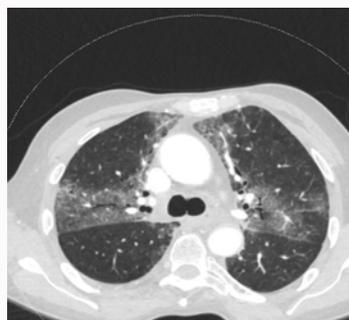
CT-scan with interstitial abnormalities of both lungs. These include ground-glass opacities and consolidation in the radiation field (anteroposterior and lateral).
